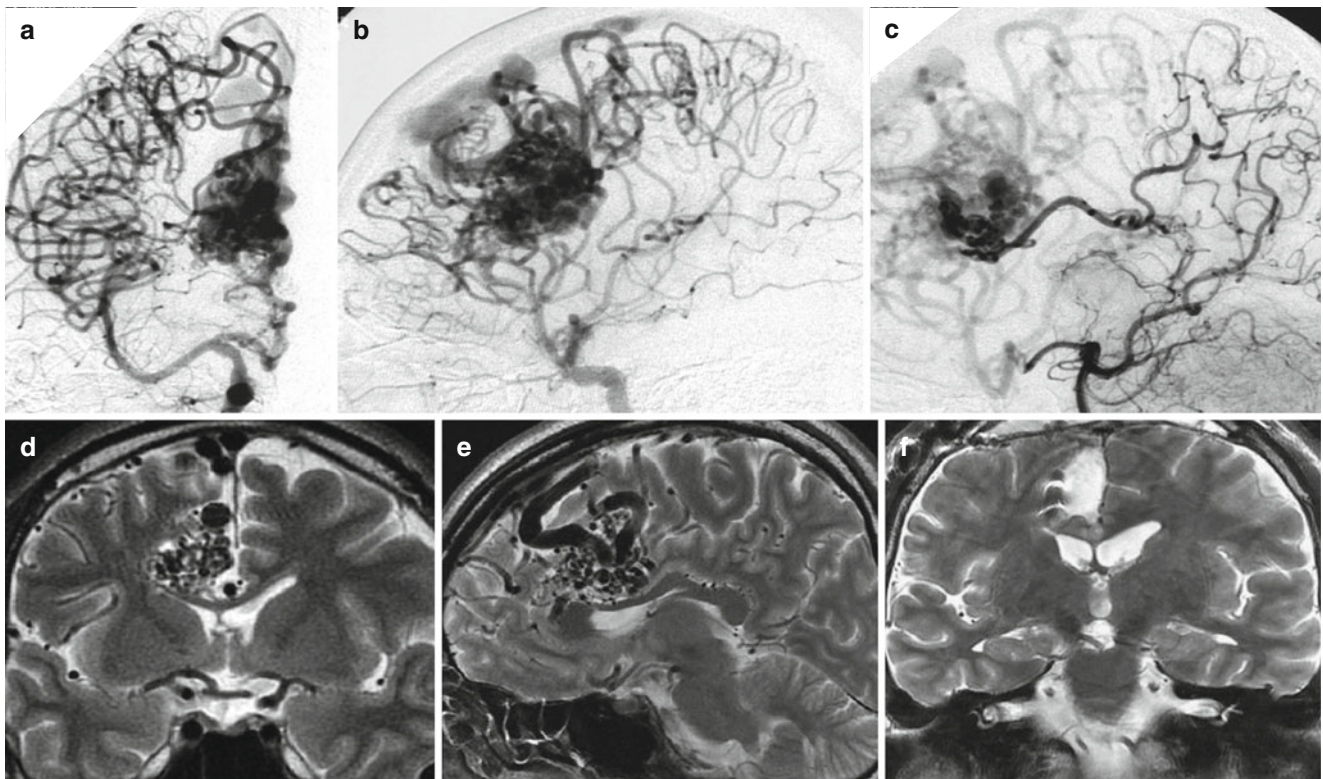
Right internal carotid angiograms (a A–P, b lateral), right vertebral angiogram (c, lateral), and T2-weighted MR (d coronal, e sagittal) showing right cingulate AVM of Case 1. Postoperative T2-weighted MR (f coronal) showing total removal of the nidus
